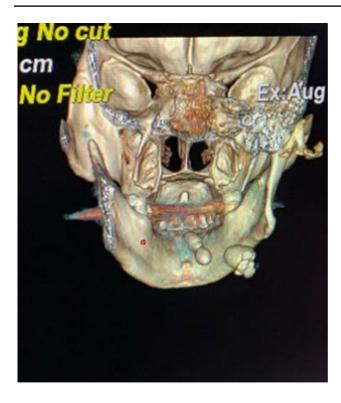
CT showing multiple stones
